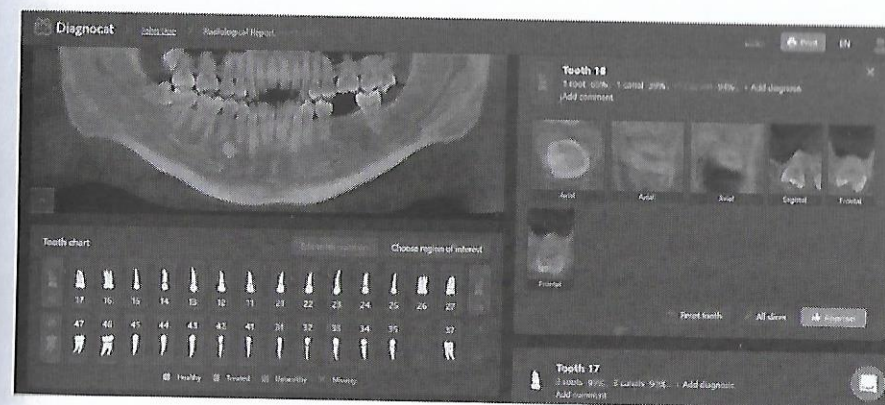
CBCT Radiographic report interface by Diagnocat
